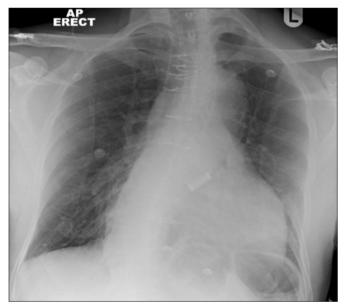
Chest Xray showing a widened mediastinum, prominent aorta and a metallic aortic valve.
